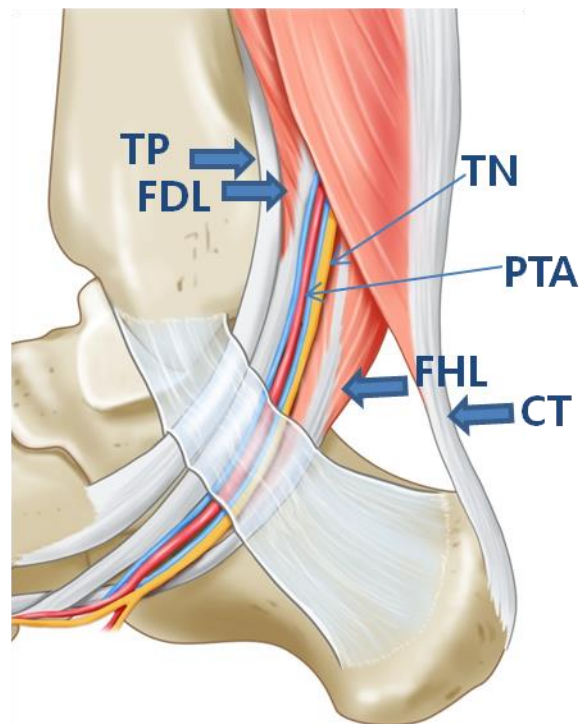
The structures that pass through the tarsal tunnel. TP, tibialis posterior; FDL, flexor digitorum longus; TN, tibial nerve; PTA, posterior tibial artery; FHL, flexor hallucis longus; CT, calcaneal tendon.
